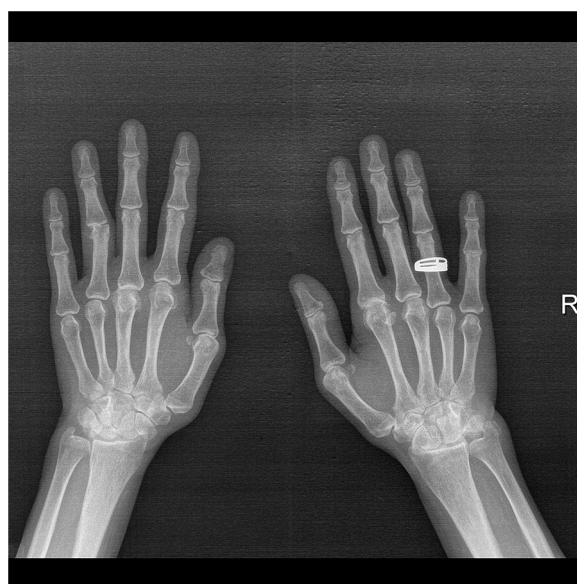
X-ray images of the hands showing signs typical of rheumatoid arthritis, such as joint space narrowing, bone erosions and some subluxations of metacarpophalangeal and interphalangeal joints.
